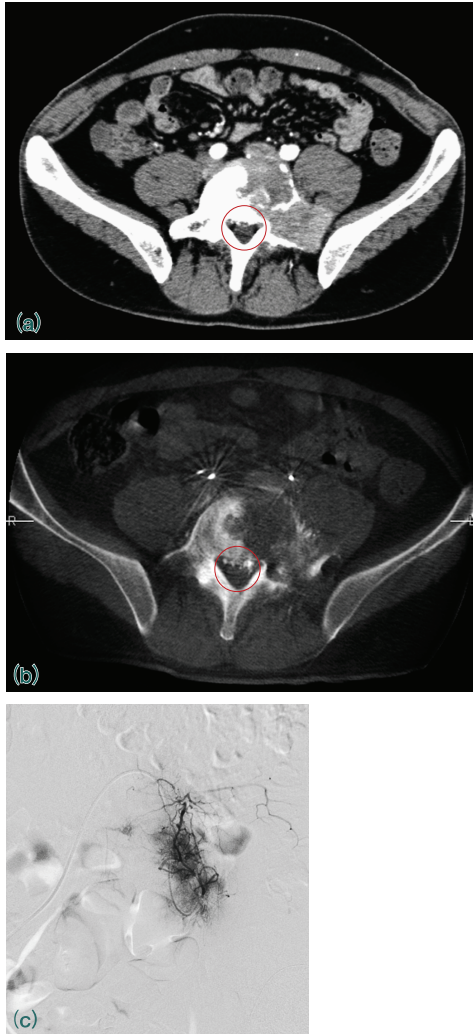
CT-Like Imaging of TAE on Bone Tumor on the Fifth Lumbar Vertebra
